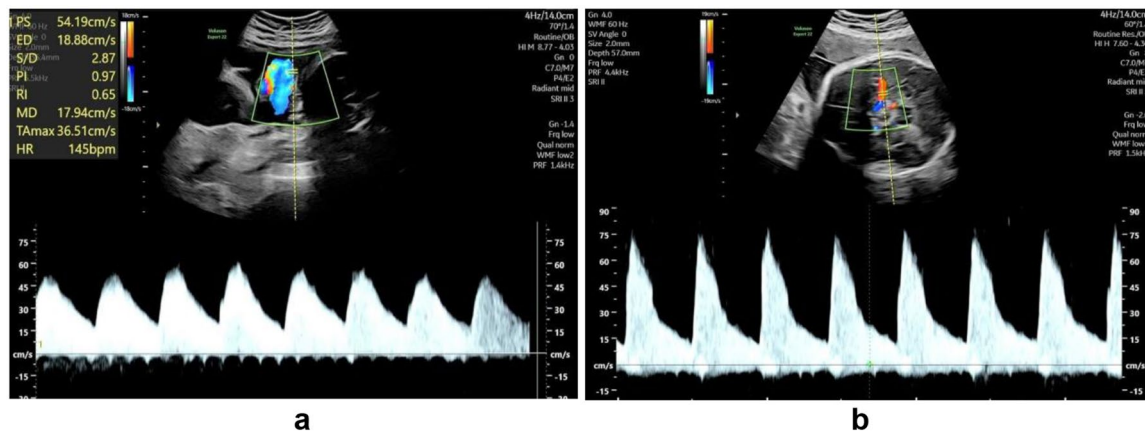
Fetal Doppler ultrasonography measurements: (a) MCA velocity waveform measurement; (b) UA velocity waveform measurement.
